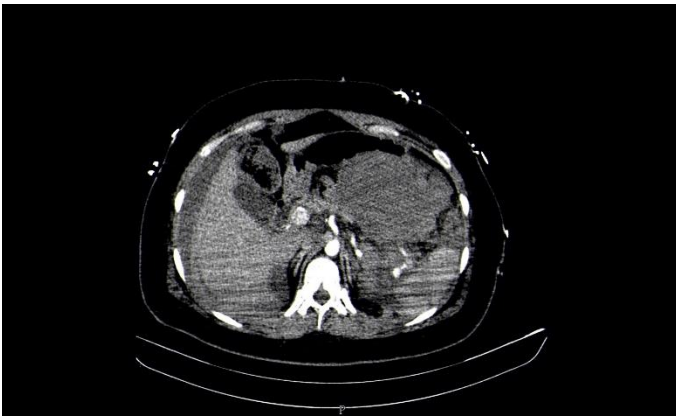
CT Scan - splenic artery rupture + hemoperitoneum
